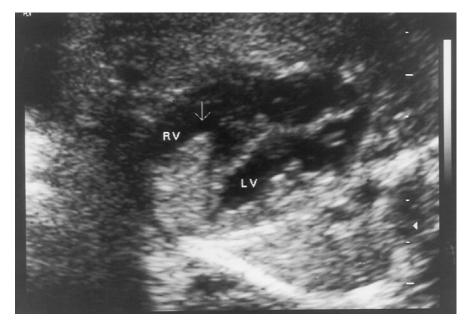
Antenatal sonographic image of a large intracardiac echogenic mass, which was postnatally diagnosed as a rhabdomyoma. Arrow indicates tip of mass; RV = right ventricle; LV = left ventricle.
